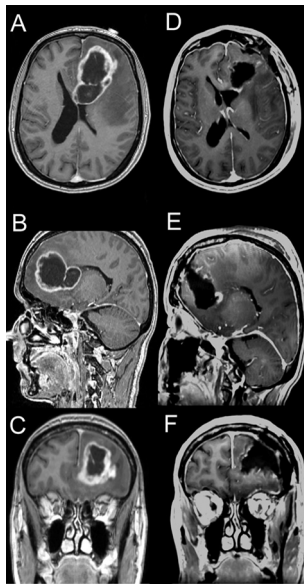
Case #1 (Table 1); MR images: axial T1 (A, D), sagittal T1 (B, E) and coronal T1 (C, F). All images are contrast-enhanced T1-weighted. Before surgery: fig. A, B, C images showing a large left frontal tumor predominantly cystic producing a mass effect on the adjacent structures. Postoperative images 2 day after surgery: fig. D, E, F images showing a good tumor resection but persistence of a little tumor residue taking the contrast in the wall of the left lateral ventricle.
